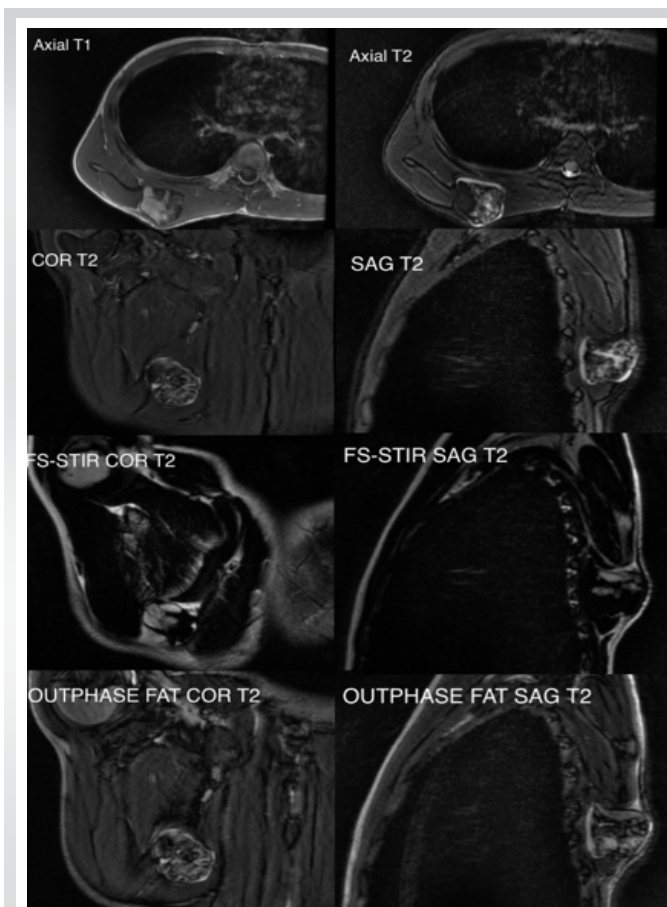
Magnetic resonance imaging sequences (sagittal, axial, and coronal) delineated a visible cartilaginous cap with surrounding fatty marrow and edema. Fat-suppressed short tau inversion recovery images (sagittal and coronal) obtained, which showed high signal intensity (cartilage) and the thickness of cartilaginous cap to be 14 mm. Out-of-phase (Opposed phase) fat-suppressed images showed hyper-intense signal depicting near total tumor replacement of the osseous lesion.
